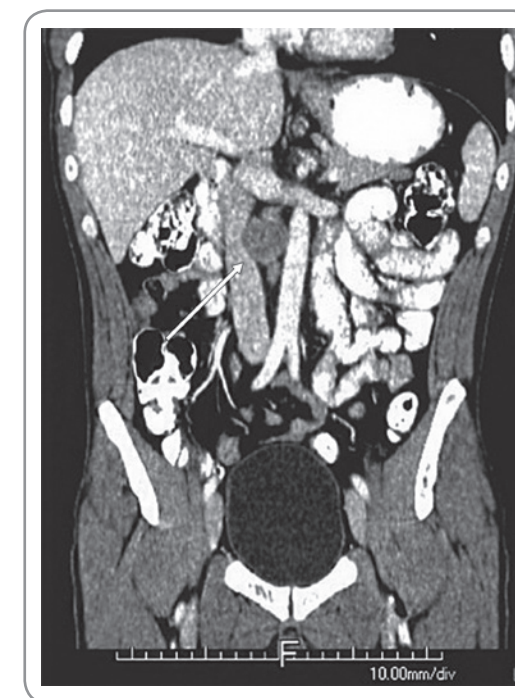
Abdominal computed tomography (CT) scan of retroperitoneal recurrence.
